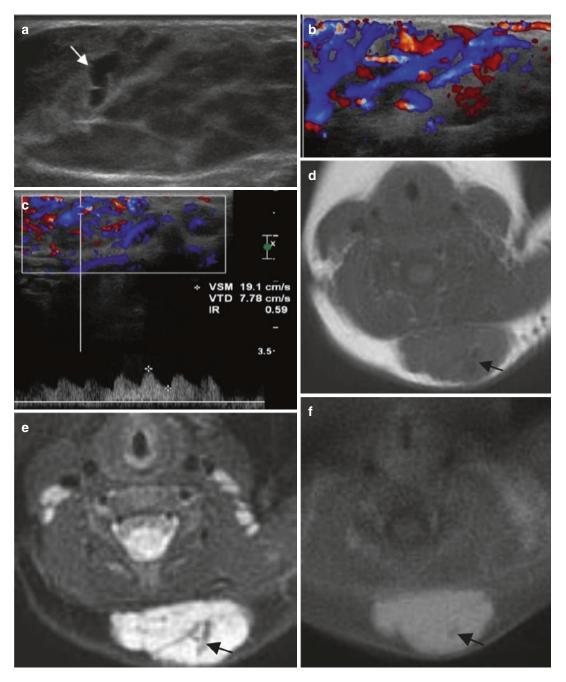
Infantile hemangioma. Nine-month-old boy with subcutaneous mass in his posterior cervical neck. (a) Axial Ultrasound. (b) Axial color Doppler ultrasound. (c) Spectral analysis obtained in tumor center. (d) Axial T1-weighted MR image, (e) Axial T2-weighted MR image, with fat suppression. (f) Axial T1-weighted MR image after Gadolinium contrast administration with fat suppression. (a–c) Ultrasound shows a solid mass with well-defined margins in the subcutaneous soft tissues of the neck (a). The lesion is predominantly hyperechoic with scattered hypoechoic foci that correspond to vessels
